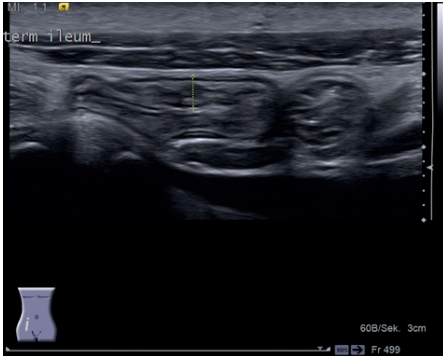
Ultrasonography showing intestinal wall thickening, diffuse layering of the terminal ileum (4.3 mm), and an inflammatory reaction of the attached mesenteric.
